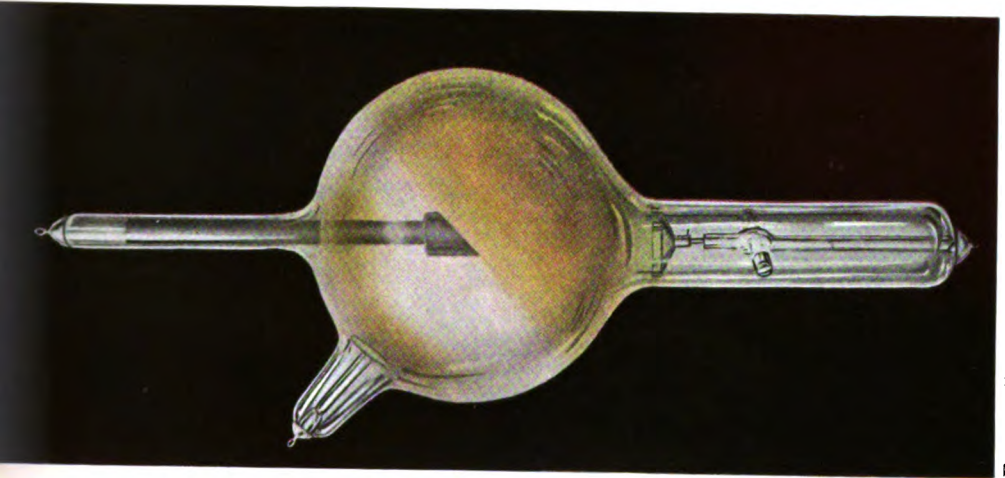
X-ray tube in operation. Vacuum too high. Resistance 8 inches, or 20 cm.
